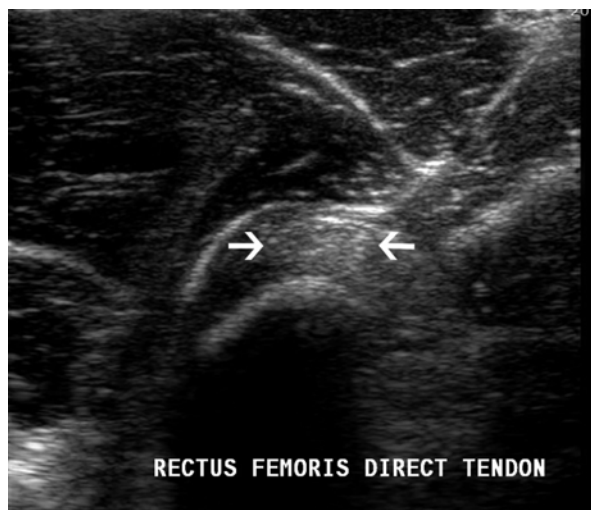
Normal ultrasound axial scan of the tendon (*white arrows*) over the AIIS
